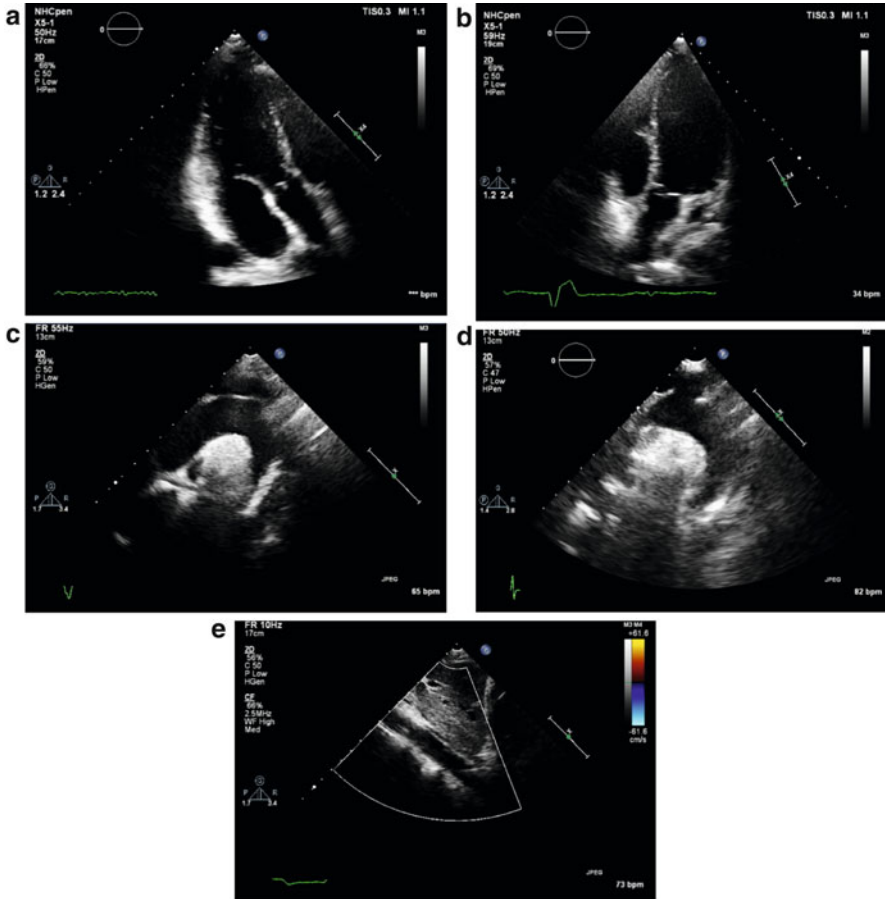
(a–e) View of different aortic segments from the various echo windows such as the apical three-chamber view (a), apical five-chamber view (b), modified suprasternal view (c), suprasternal view (d), and subcostal view (e)
